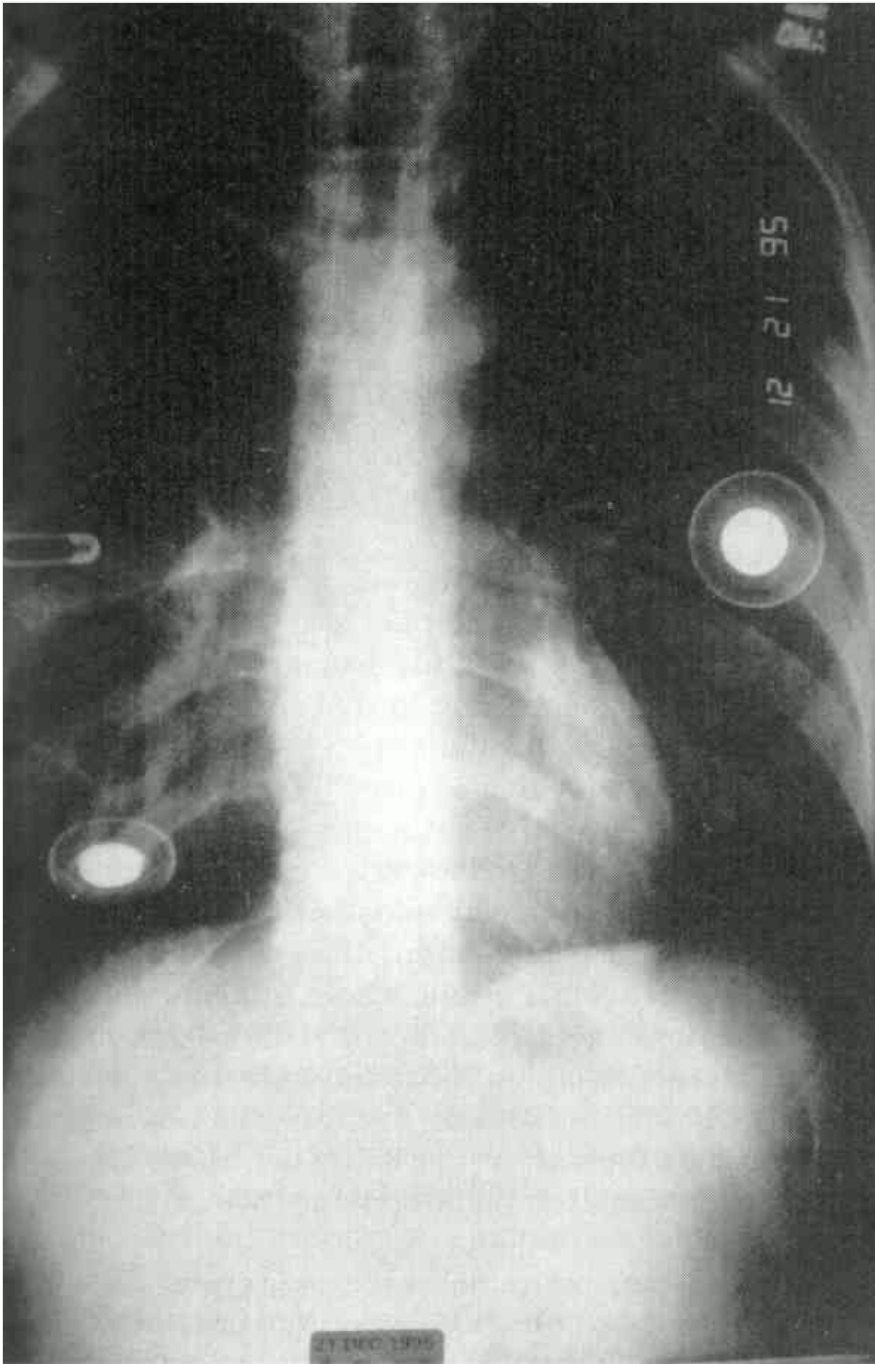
Upright chest x-ray showing the disparity in the position of the fill ports.
